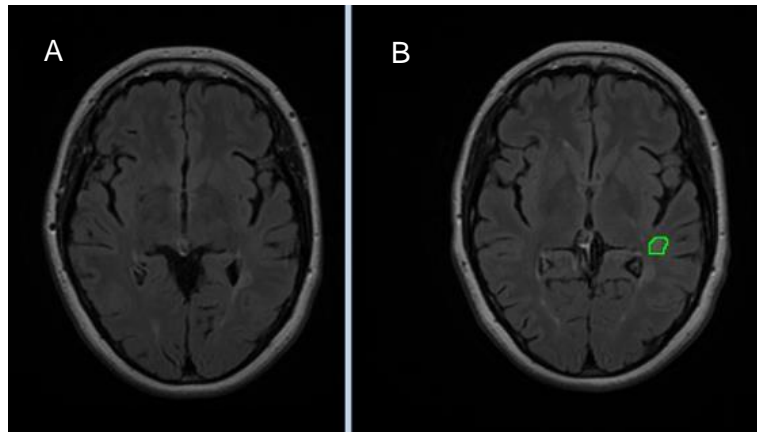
(A) initial FLAIR MR image (B) Demonstration of new T2 lesion (ROI) on final FLAIR MR image; time interval of 6 months between the two scans.
